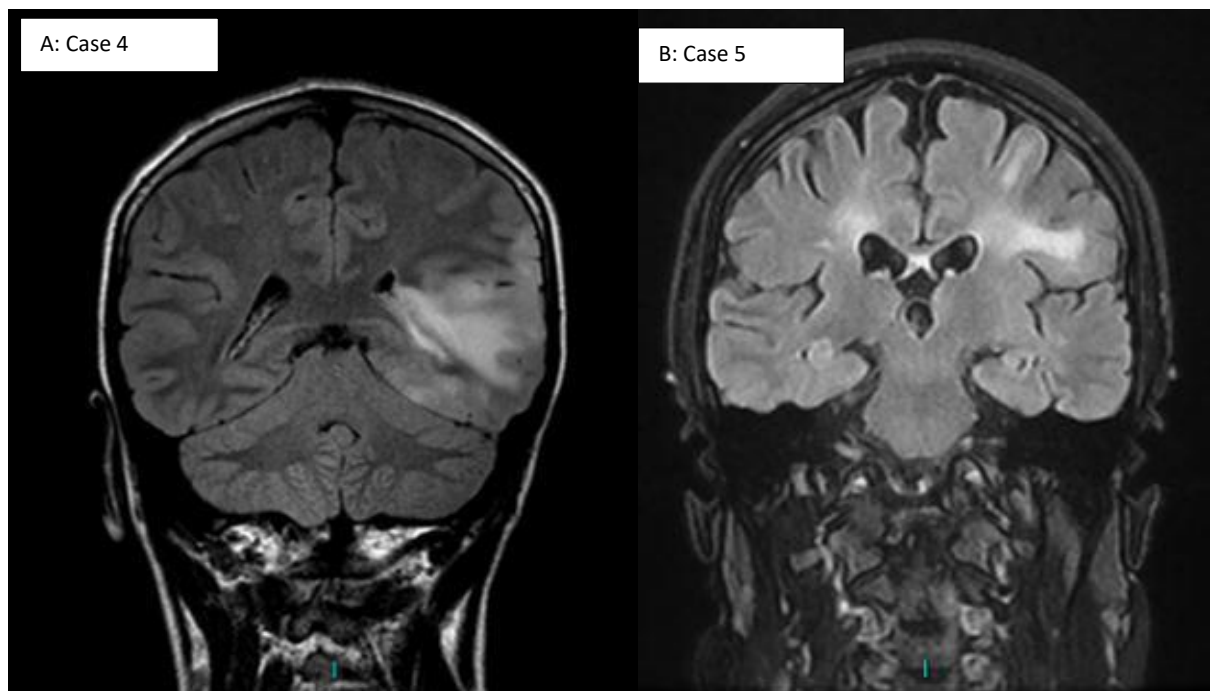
MAGNETIC RESONANCE IMAGING OF THE BRAIN, CASES 4 AND 5
